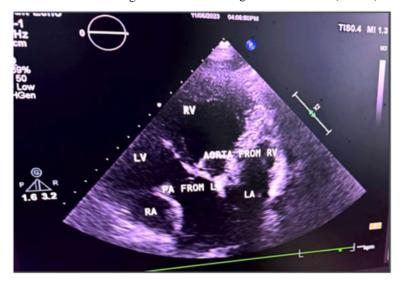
2D echocardiographic image showing the aorta arising from the right ventricle (RV) and pulmonary artery from the left ventricle (LV).
